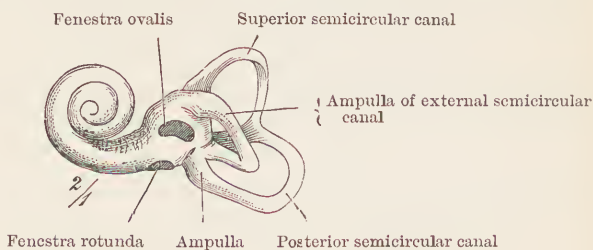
CAST OF LEFT OSSEOUS LABYRINTH, EXTERNAL ASPECT. (Pansch.)
